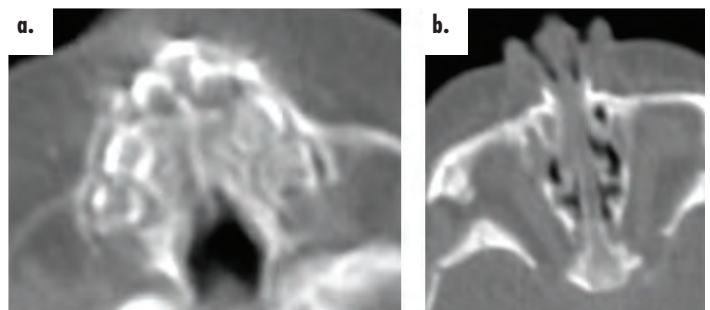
Selected axial images from CT with contrast performed on patient in Case 1 at 17 days of age. Axial sections of CT display both developing primary solitary median maxillary central incisor (a) and congenital pyriform aperture stenosis with narrowing of nasal cavity and choana (b).
